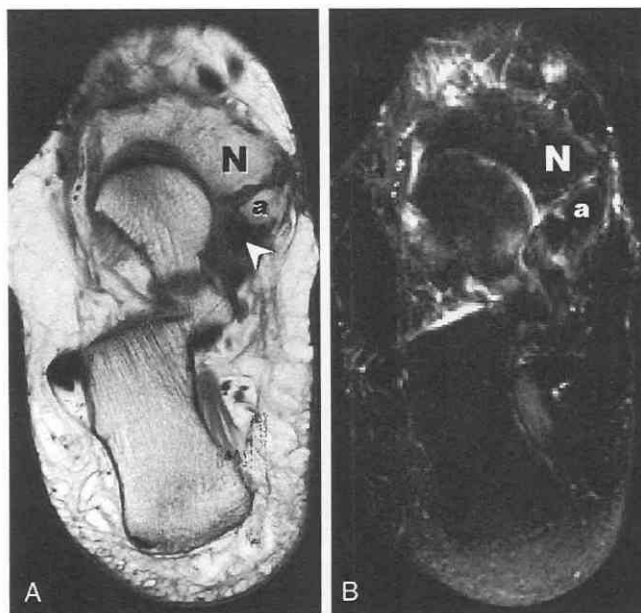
The patient is a 59-year-old woman with medial point tenderness. *A*, Axial T1-weighted image demonstrates an accessory navicular bone (a) separate from adjacent navicular (N). The posterior tibial tendon inserts on the accessory navicular (arrowhead). *B*, Axial fat-suppressed T2-weighted image at the same position as *A*. The line of fluid between the accessory navicular and the navicular indicates an abnormal joint between these two bones instead of a solid fibrous synchondrosis.
